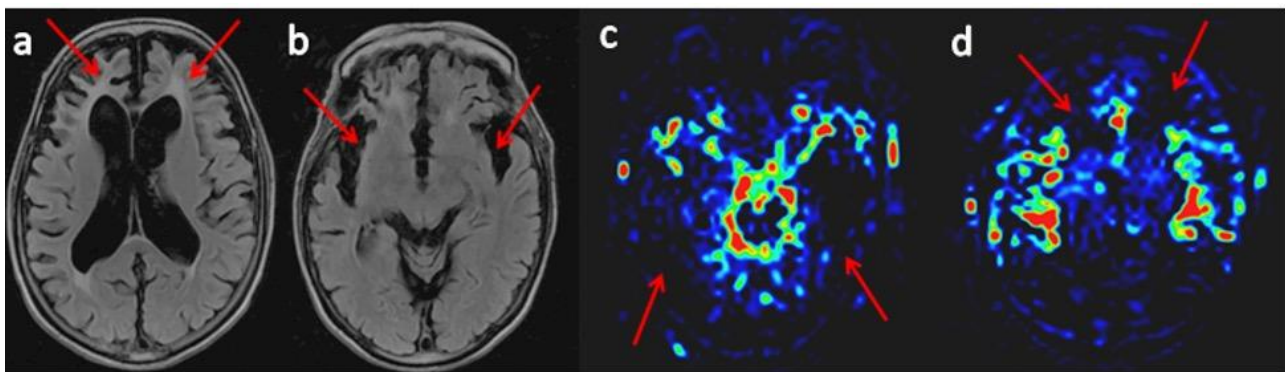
(a, b): MRI: Axial FLAIR images showing mild atrophy in the frontal & temporal lobes (arrows) with corresponding (c, d) ASL images depicting gross decrease in perfusion in bilateral frontal and temporal lobes.
